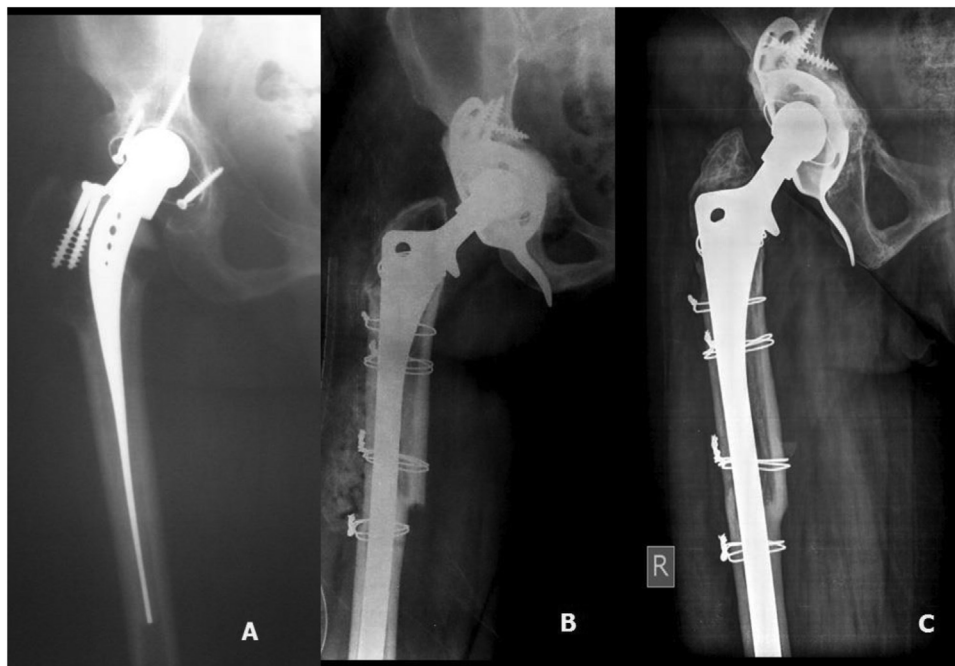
(A) Radiograph of a loosened isoelastic stem 15 years after primary THA in a 51-year-old female with type II Paprosky defect (B) Revision of stem with an extensively porous coated long stem (C) Ten years post surgery showing stable, well-fixed implant and good consolidation of ETO.
